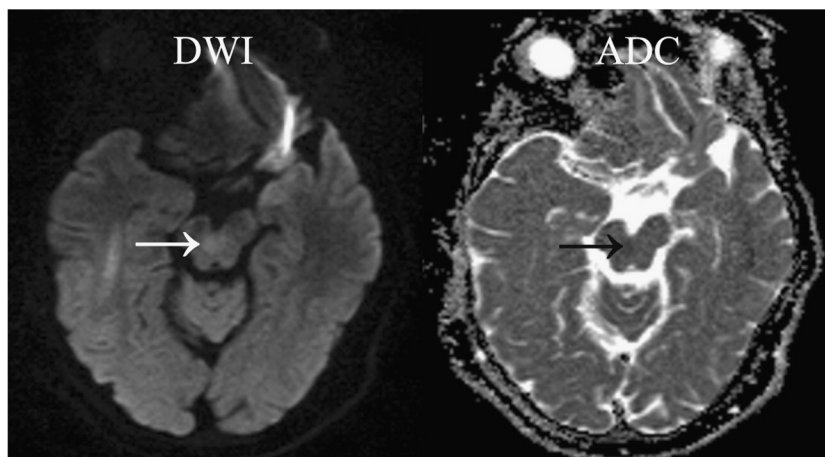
Axial DWI (TR/TE=3200/94 ms, $b=1000$ s/mm², phase encoding direction with right to left) and corresponding ADC map without neurological findings. The IPR of the midbrain (IPR) displayed high signal in a 65-year-old woman (white arrow), relative to the PAG. The ADC value of the IPR was 0.67×10^{-3} mm²/s on the corresponding ADC map (black arrow).
